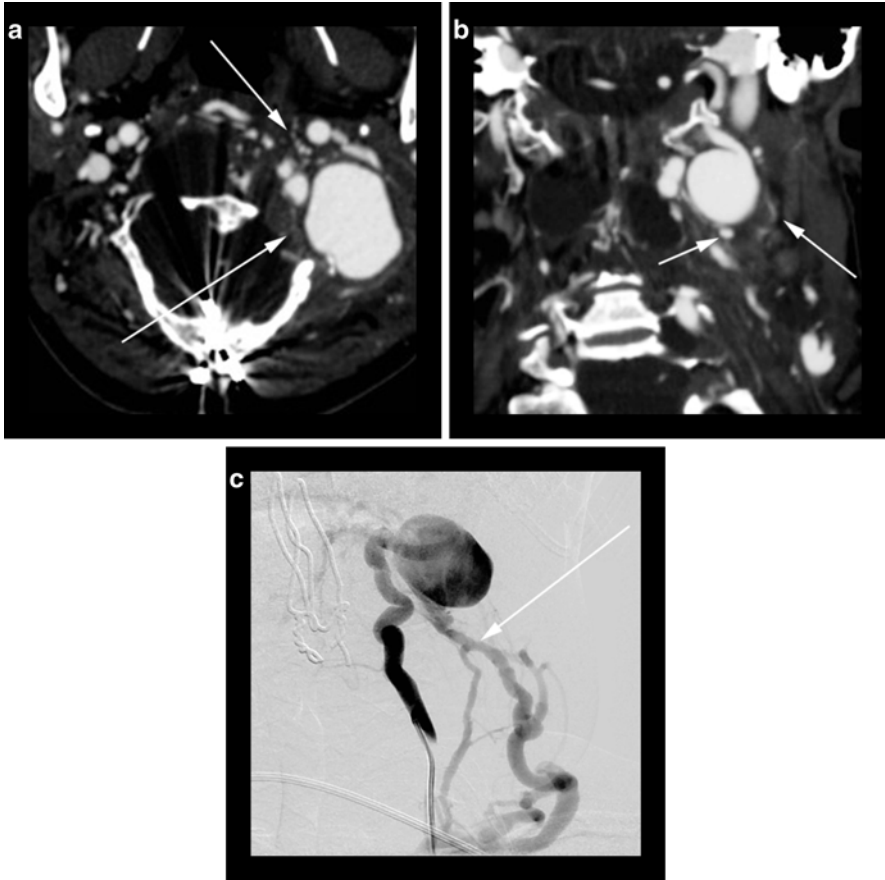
Adult patient with neurofibromatosis type I presented with rapid onset of neck pain. (a) Axial CTA image shows a giant aneurysm (*bottom arrow*) arising from the left vertebral artery with arterialization of surrounding small venous structures (*top arrow*). Surgical changes related to prior craniocervical junction decompression are also noted. (b) Coronal CTA image displays the relationship of the aneurysm (*right arrow*) to surrounding structures (*left arrow*). (c) Oblique projection DSA image with injection of the left vertebral artery shows opacification of the venous structures (*arrow*) surrounding the giant aneurysm
